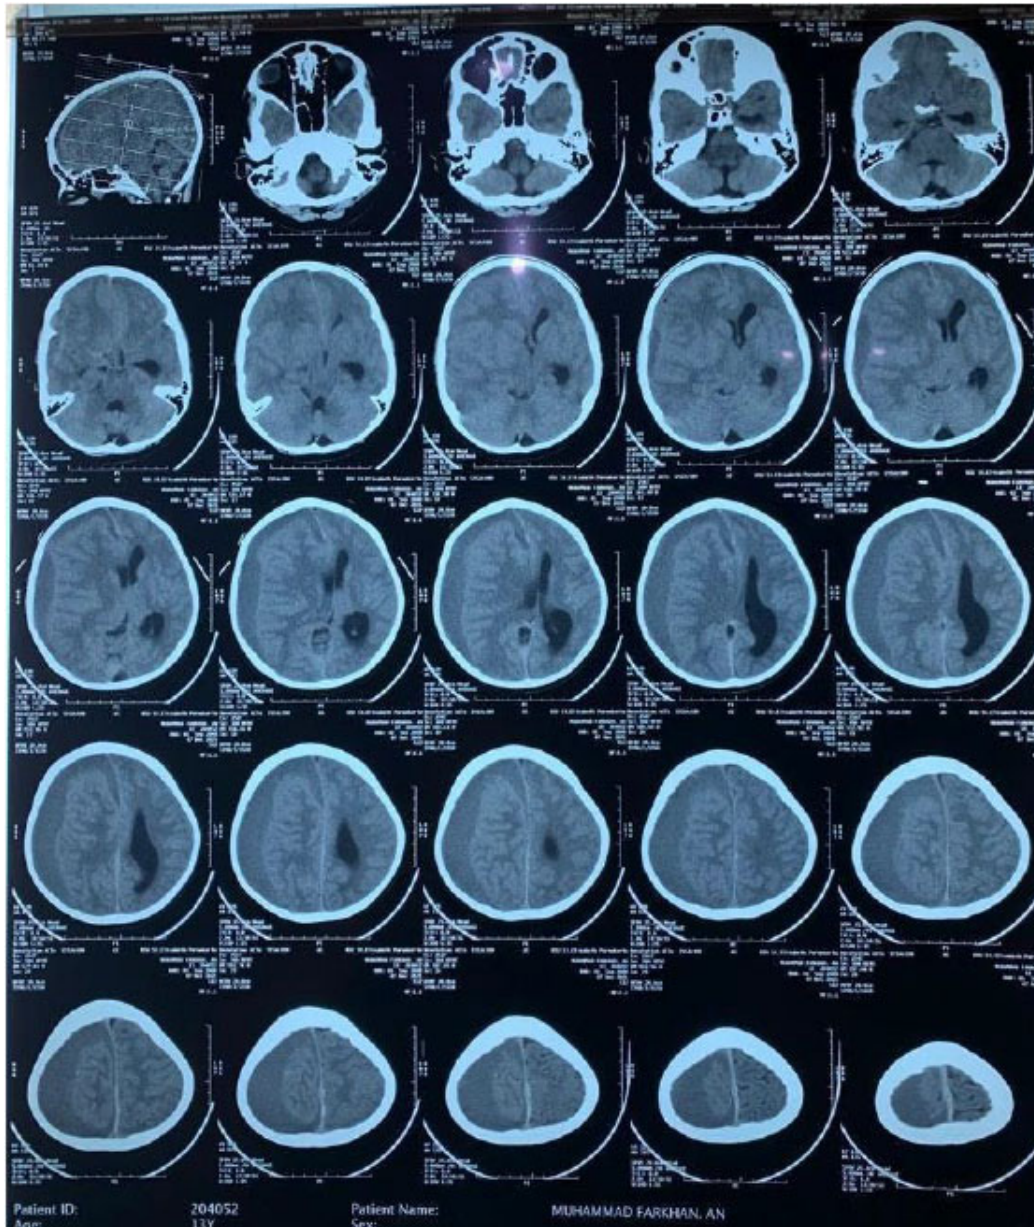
Head computed tomography scan showing chronic subdural hematoma on the right frontoparietooccipital lobe.
